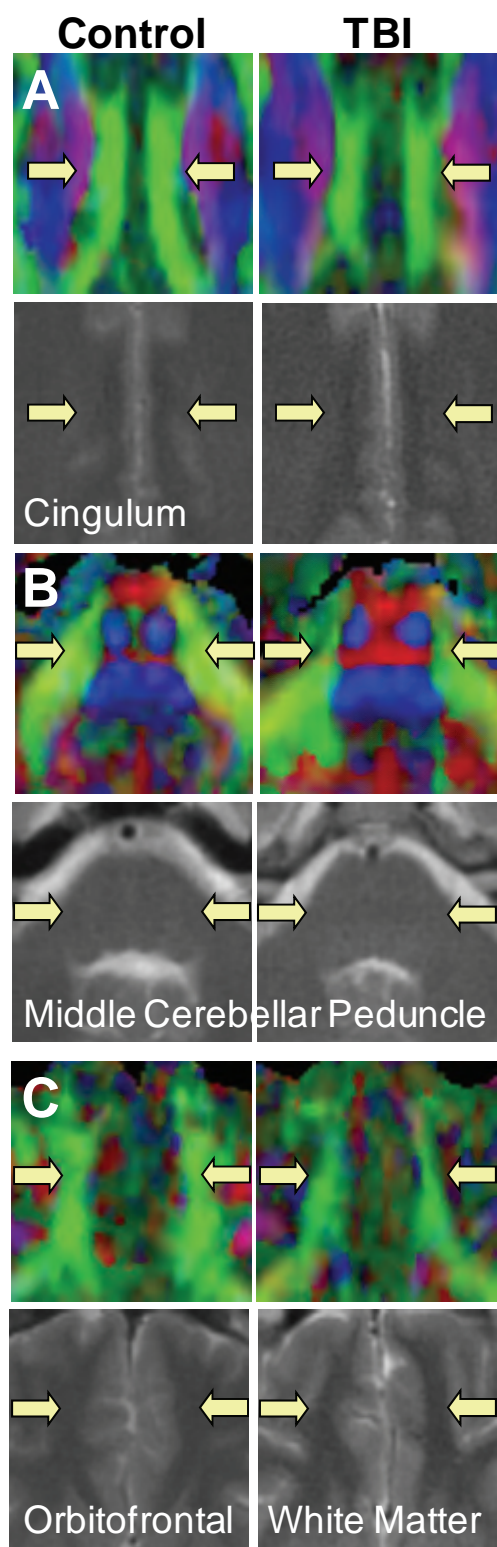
DTI reveals abnormalities after blast-related TBI that are not apparent on conventional MRI. Top panels: DTI relative anisotropy maps. Colors indicate principal diffusion directions: red = right-left, green = anterior-posterior, blue = dorsal-ventral. Brighter colors indicate higher relative anisotropy. Arrows indicate regions with abnormally low relative anisotropy on DTI in the TBI subjects compared with controls. Bottom panels: conventional T2-weighted MRI showing no detectable abnormalities at the same locations in the same subjects. Small differences in the appearance of the T2 weighted images are due to normal subject-to-subject variability. A. Cingulum bundles. B. Middle cerebellar peduncles. C. Orbitofrontal white matter.
